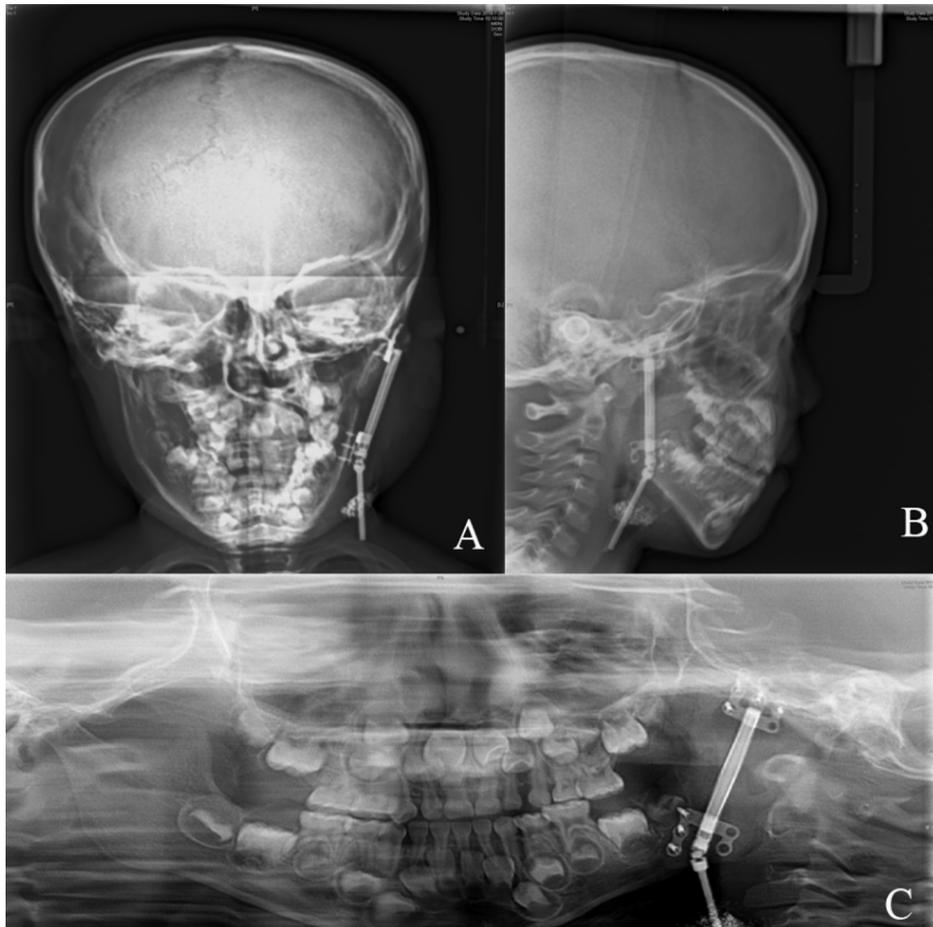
A and B: Posteroanterior and lateral cephalograms of the completed distraction process for the affected mandible. C: Panoramic radiographs used to identify the occlusal plane following completion of the distraction process.
